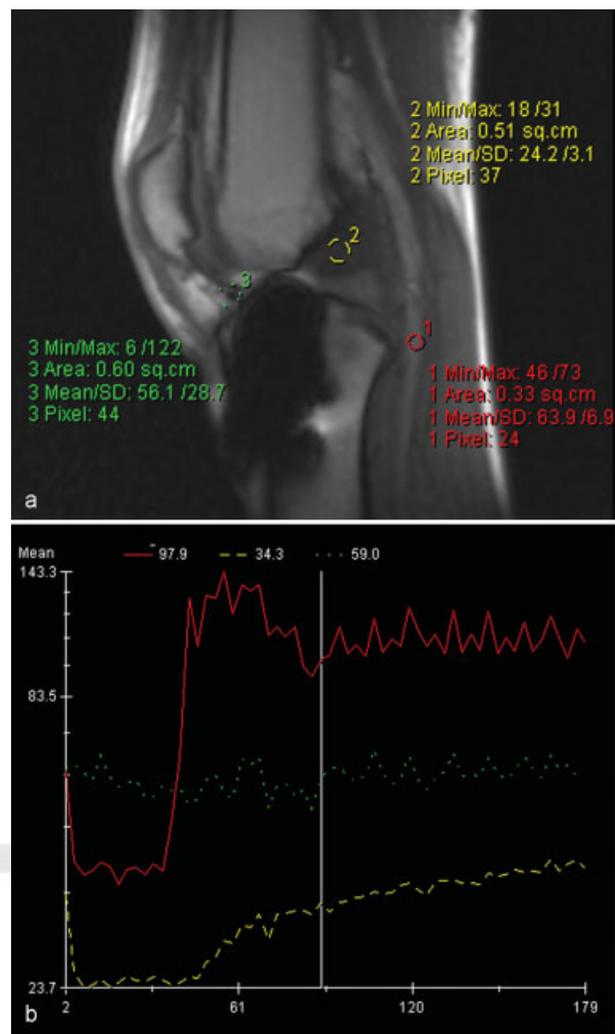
Dynamic contrast-enhanced MRI after dynamic intraligamentary stabilization of the anterior cruciate ligament (ACL). (a) Region of interest measurements in ACL repair tissue (yellow), Hoffa scar (green), and popliteal artery (red). (b) Dynamic contrast curve shows marked hypervascularity of ACL repair tissue compared with lower vascularity in the postoperative scar.
